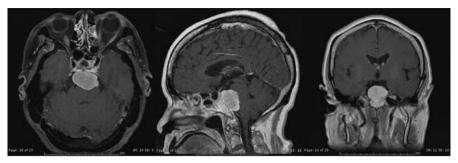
Clivus meningioma in an 84-year-old woman. A gadolinium-enhanced axial, sagittal and coronal MRI showing classic imaging features of a meningioma arising from the middle third of the clivus. Note the marked, homogeneous contrast enhancement and thickened dural enhancement inferior to the tumor along the lower clivus. The vertebrobasilar vessels are displaced to the right and the brainstem is markedly distorted
